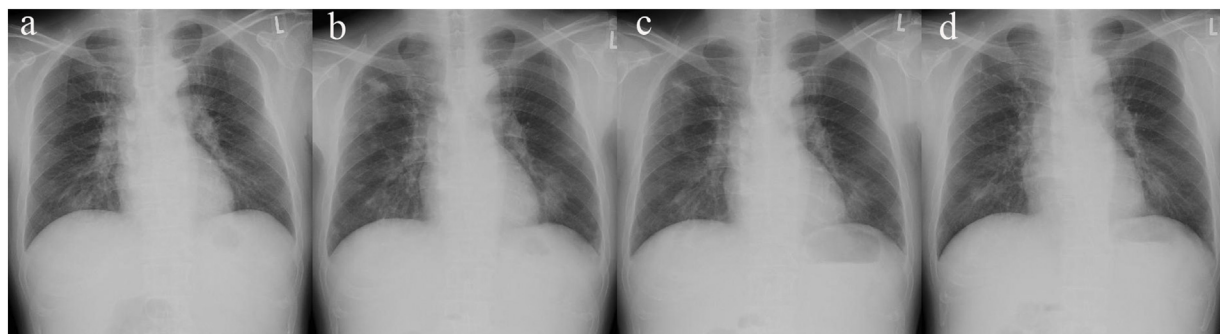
Time course of chest x-ray imaging. At the time of admission, there was only an invasive shadow in the lower right lung field (a), but multiple nodules and invasive shadow appeared bilaterally on day 12 (b). With anti-fungal drugs and surgery, these shades gradually improved by day 27 and 36 (c,d).
